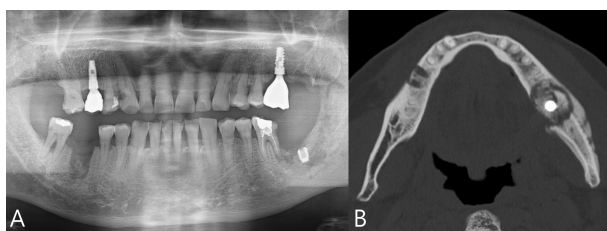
Panoramic radiograph (A) and computed tomography (B) showing formation of sequestrum around dental implant on left side of mandible and extraction socket on right side of mandible.
